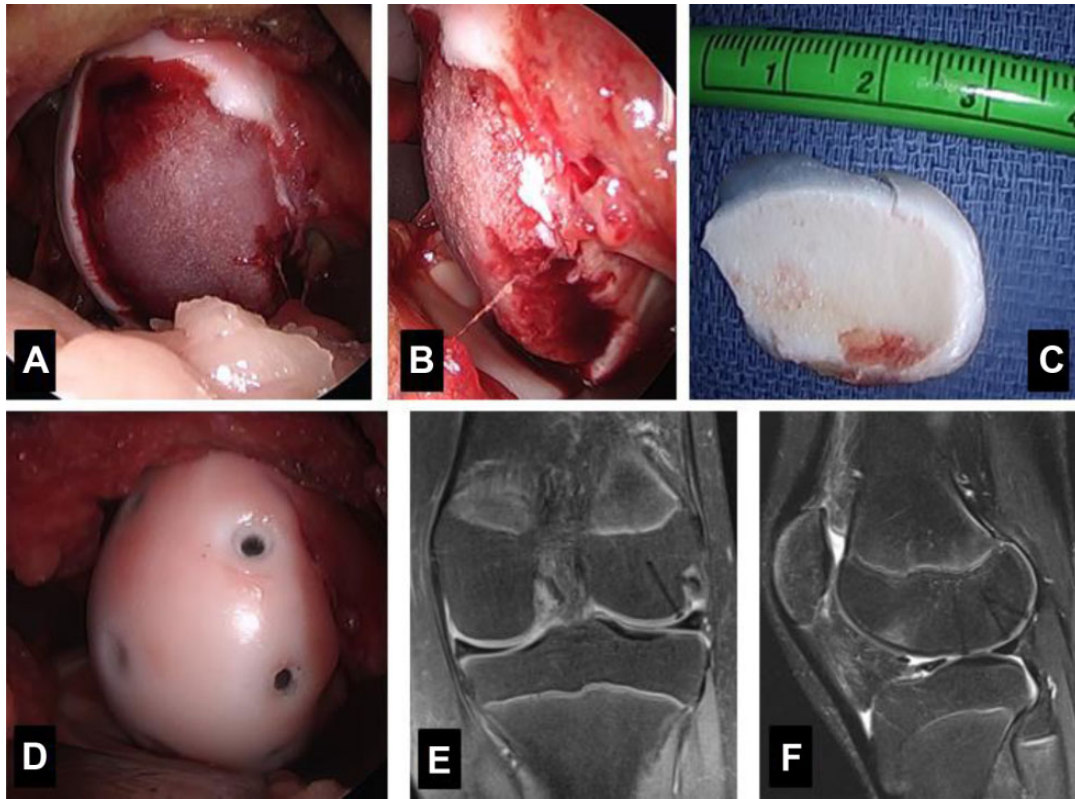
A 12-year-old female gymnast sustained a twisting injury on landing, resulting in a large chondral shear injury of the lateral femoral condyle. (A) Frontal and (B) side intraoperative images reveal a denuded lateral femoral condyle with intact subchondral bone. (C) The chondral fragment measured 21 mm × 30 mm, had no bone, and was comprised only of articular cartilage. (D) It was anatomically repaired using absorbable tacks. (E) Coronal and (F) sagittal T2-weighted turbo spin echo magnetic resonance imaging sequences with fat suppression (Magnetom Verio 3 T; Siemens) obtained 3 months postoperatively reveal early healing with an intact cartilage contour with no evidence of tack migration.
